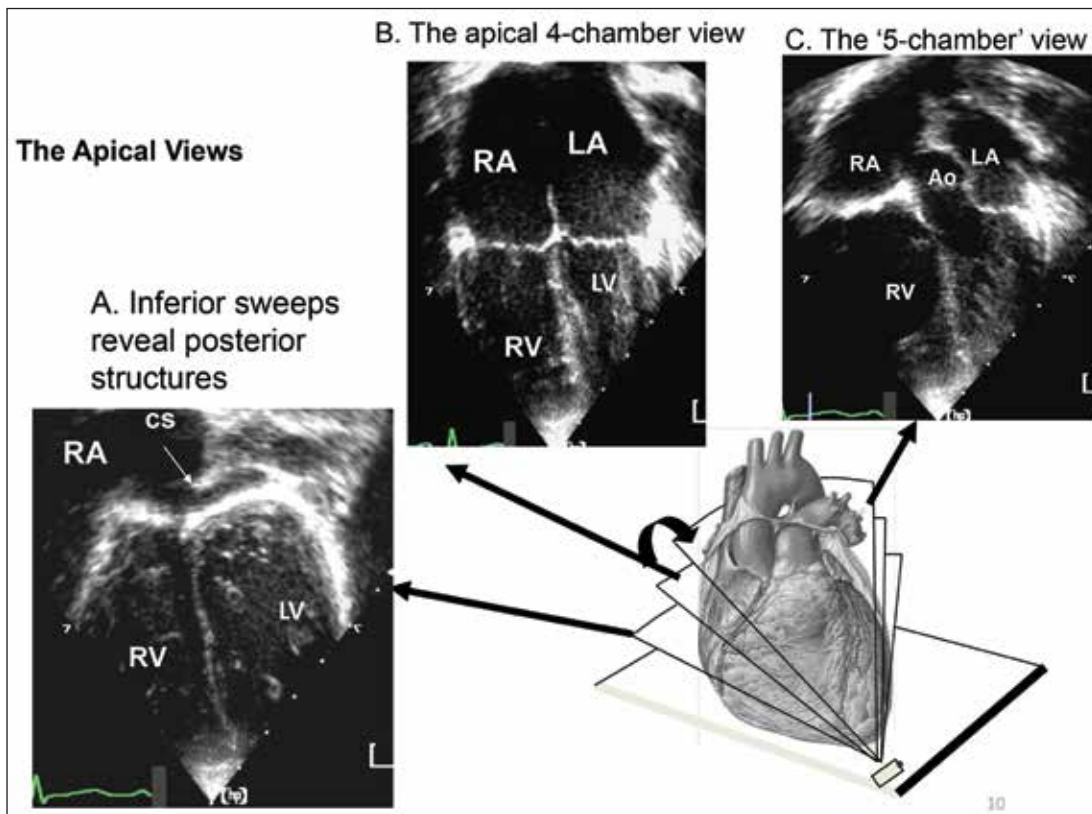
Transducer position and imaging planes for the Apical four and five chamber views. Posterior structures such as the coronary sinus and posterior ventricular septum are seen in the inferior cuts (A); by sweeping superiorly the mitral and tricuspid valves are profiled (Classic apical 4-chamber view); further sweep superiorly reveals anteriorly located left ventricular outflow tract and aortic valve.
